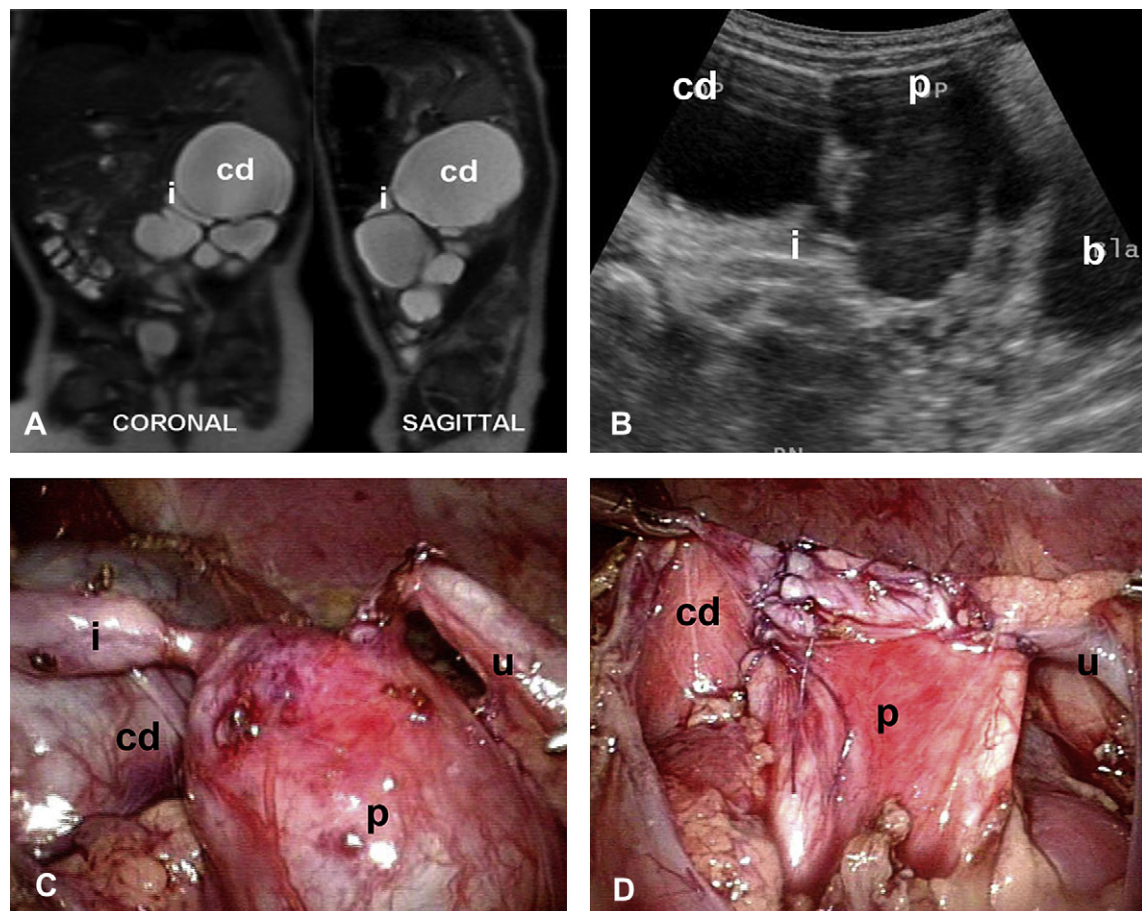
Preoperative MRI nephrography (A) and ultrasound examination (B) showed dilation of the left renal pelvis in a horseshoe kidney. A duplicated collecting system was suspected, but intraoperative exploration (C) revealed a large calyceal diverticulum (cd) with a narrow infundibulum (i) and dilation of the renal pelvis due to an UPJ obstruction. (D) Anastomosis of the dismembered pyeloplasty (u: ureter) as well as between the calyceal diverticulum (cd) and the renal pelvis (p).
